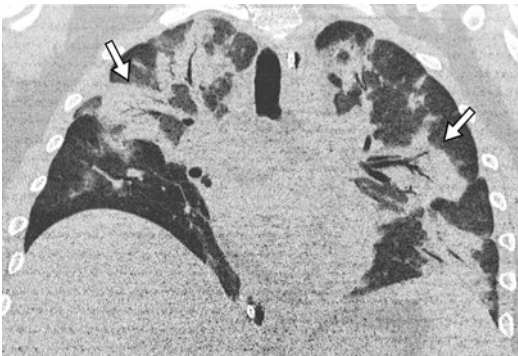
Peri-engraftment respiratory distress syndrome (PERDS) in a 25-year-old man with acute lymphoblastic leukemia. Coronal CT demonstrates bilateral areas of consolidation in a peribronchovascular distribution (arrows)
